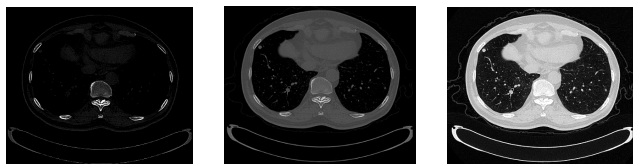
The display results of CT image in different window width and location.
